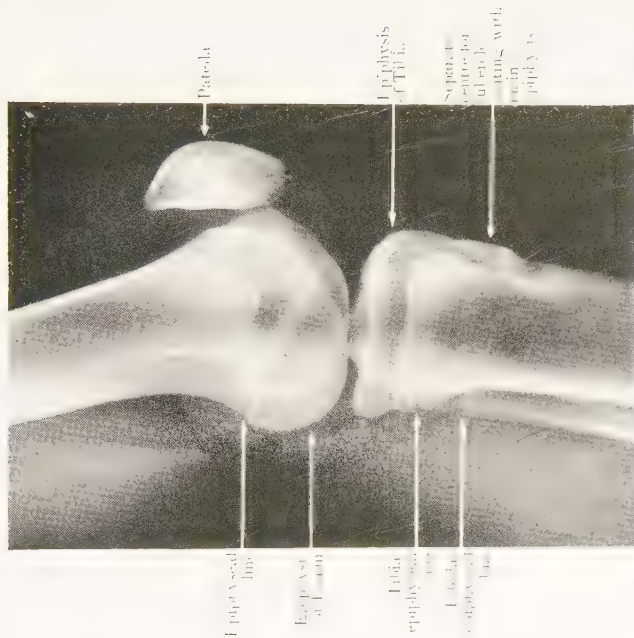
Lateral Radiograph of slightly flexed
